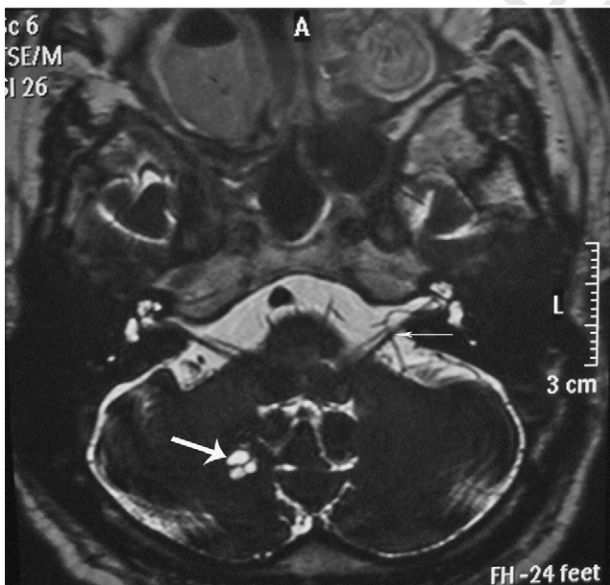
The cerebellar multilocular cystic lesion (68-year-old man with vertigo) was revealed in the right cerebellar parenchyma adjacent to the vermis (arrowheads) on the 3D drive T2-weighted MRI. We consider it as a variant of perivascular space dilatation, old lacuna infarction, or cavitory degeneration. On the left side, the IAA originated from the ipsilateral AICA and coursed into the left IAC on 3D drive T2-weighted MRI (type IB non-loop-type AICA/PICA without IAC extension).
